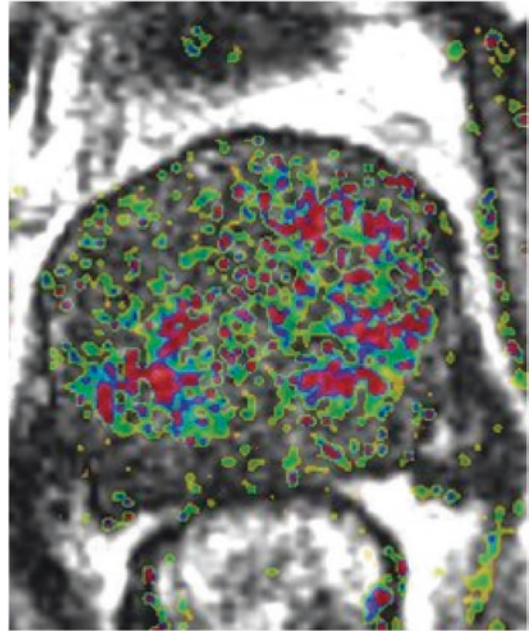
Color map reflecting the dynamic contrast-enhanced MR images of the prostate
